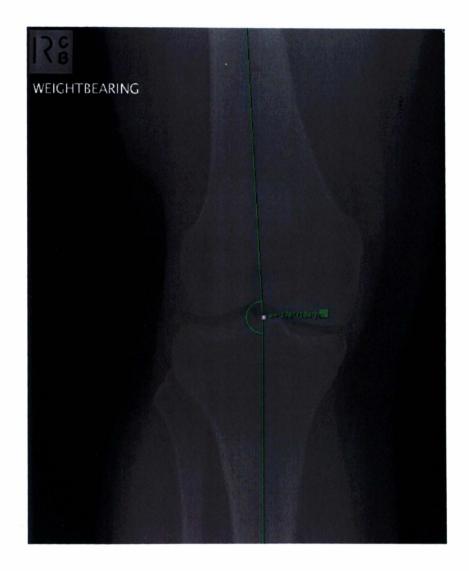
Static tibiofemoral knee angle as measured from standing AP radiographs. It is the angle subtended by the intersection of a line drawn through the middle of the femoral shaft and a line drawn through the middle of the tibial shaft [321].
